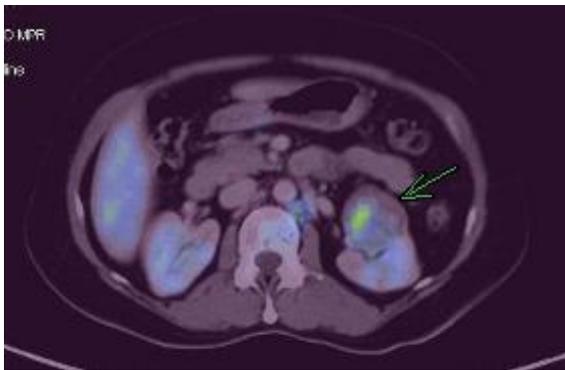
Axial PET/CT showing uptake in the kidney lesion (arrow).
